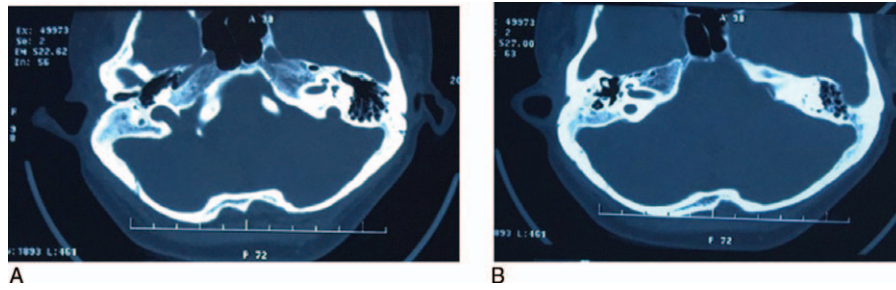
Axial CT images of the temporal bone from subject III-3 (A) Partial or complete loss in the auditory ossicle. (B) Dilatation in the bony auditory tube and defect in the internal ear and cochlea.
